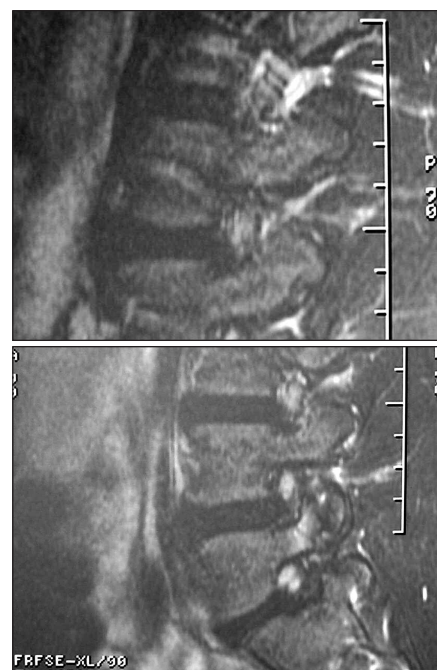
Repeat MRI following four right-sided and three left-sided PRP matrix grafts with evident interval healing.
